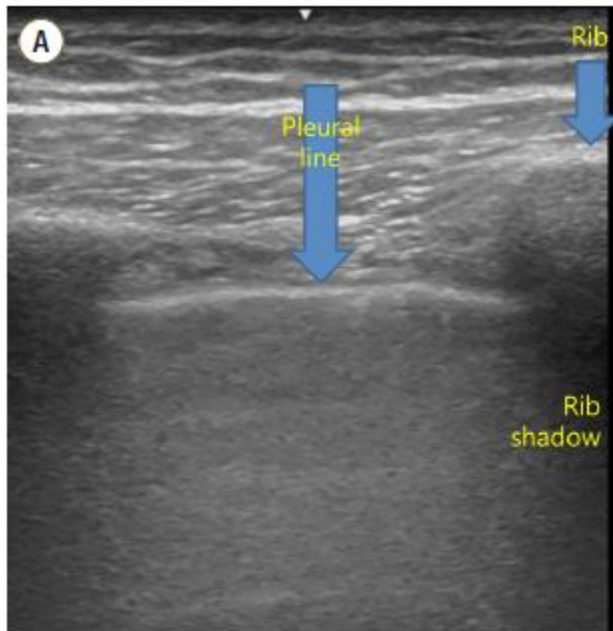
Normal findings of lung ultrasound. (A) Characteristic pleural-line and rib shadow that should be identified before starting the exam.
